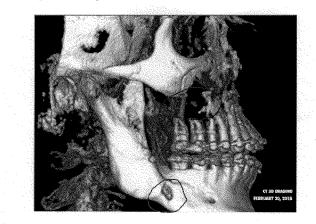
Right Side Full Volume CBCT Scan View. Further bone loss and damage. Note the Lower Right Mandible. There is a hole in the bone due to necrosis from bone shards that hardware was placed over. The inferior alveolar nerve that the surgeons admit to damaging on the right side is also exposed. This is extremely painful because when the Masseter Muscles contract or strain; it compresses the already damaged/exposed nerve.
